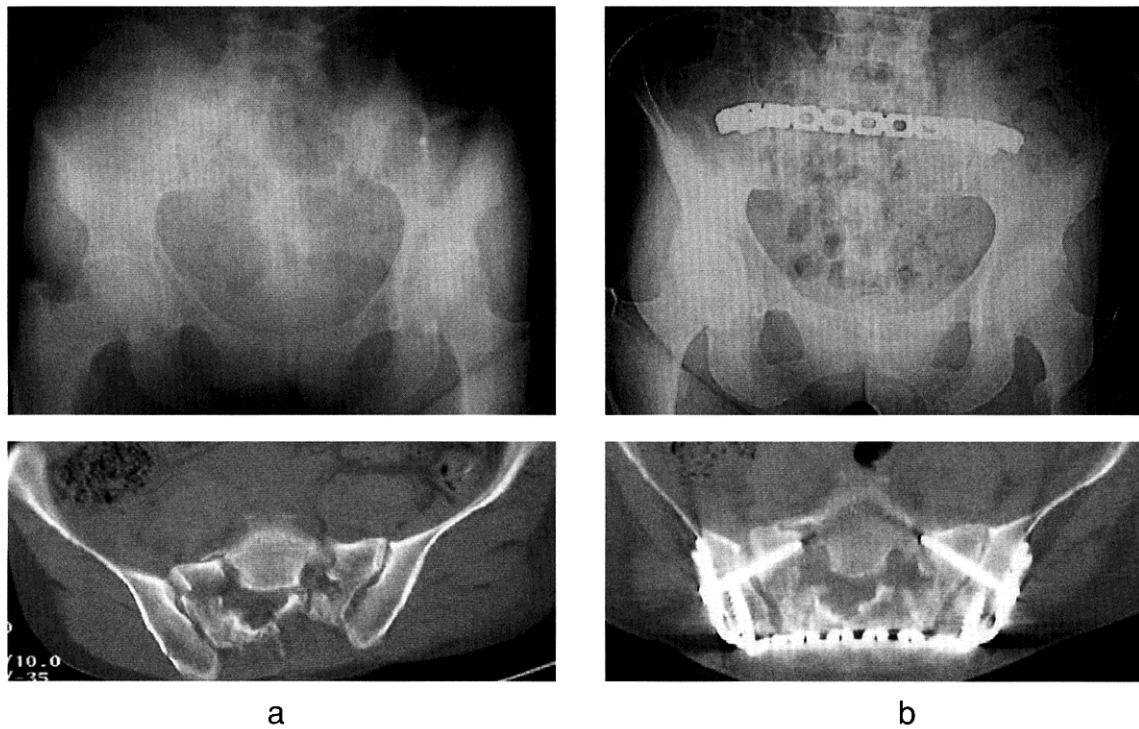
a. Preoperative AP radiography and CT, sustained bilateral Zone II sacral fractures. b. Postoperative AP radiography and CT, demonstrates use of the 4.5 mm reconstruction trasiliac plate.
